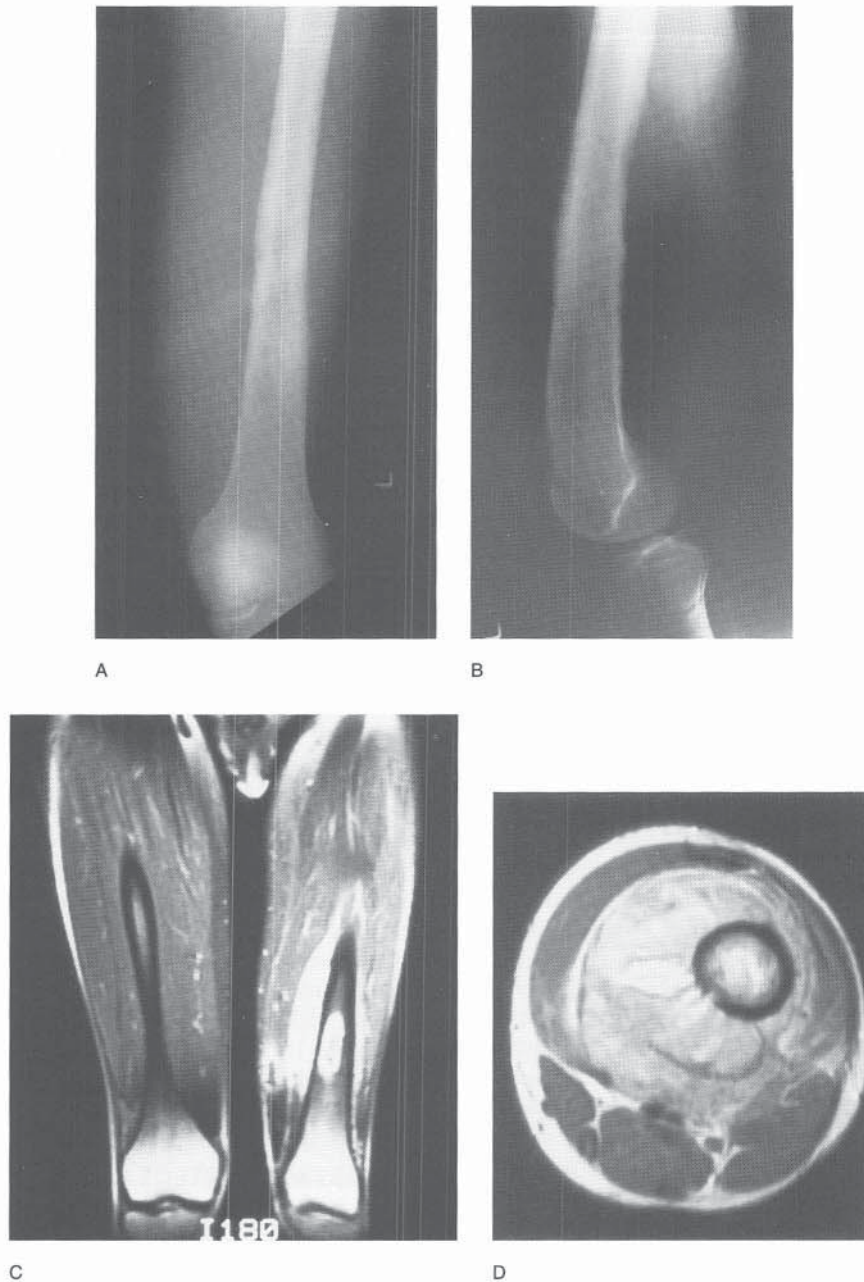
Ewing's sarcoma/PNET in a 15-year-old boy. A, AP radiograph showing a permeative, destructive lesion of the femoral diaphysis. There is a suggestion of a soft tissue mass. B, Lateral radiograph. The mass is better seen, and there is erosion of the posterior cortex. C, Coronal MR image showing the medullary extent of the tumor. D, Axial MR image showing that huge soft tissue mass almost completely surrounding the femur. This appearance is typical of Ewing's sarcoma PNET. Because the tumor does not make tumorous bone or cartilage, there is no mineralization as is seen in osteosarcoma. A biopsy confirmed the diagnosis of Ewing's sarcoma/PNET.
